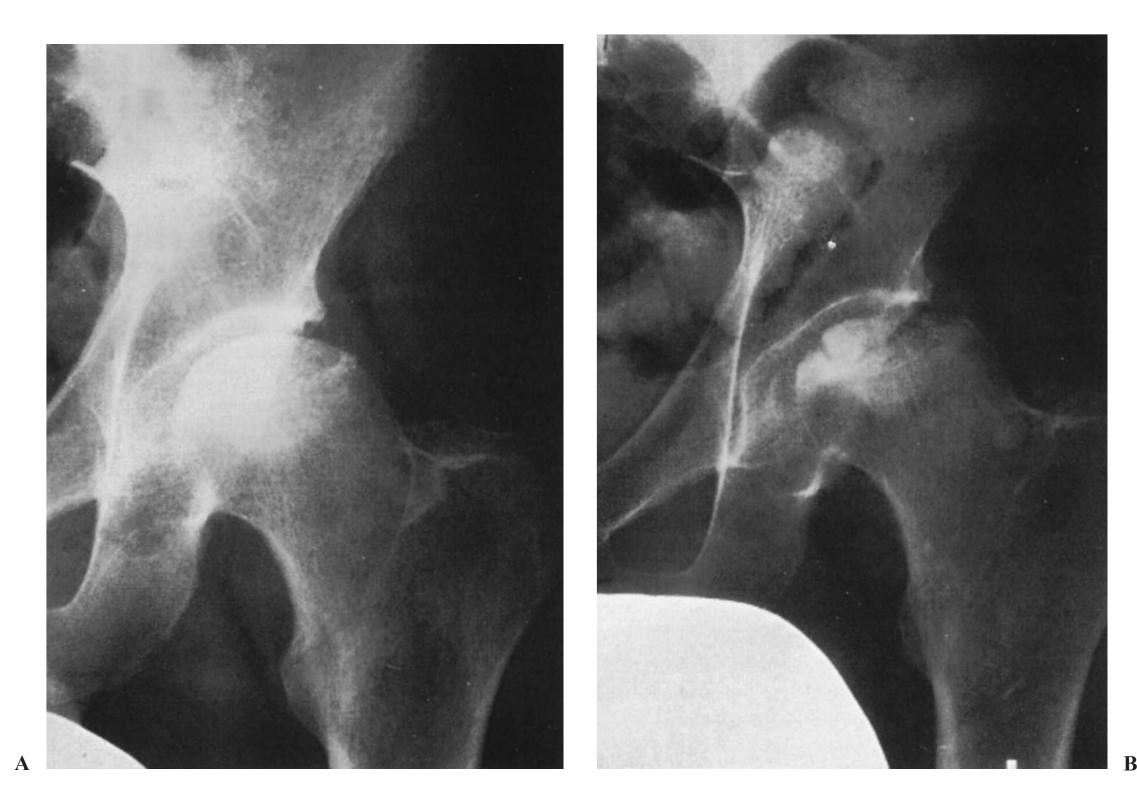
An avascular necrosis of the head of the femur after transplantation. A. A normal radiograph of the hip 10 months after transplantation, at which time the patient was complaining of pain. B. The same hip 8 months later. This patient had received azathioprine and high-dose steroids and subsequently had a successful hip replacement. (From Morris PJ. *Kidney Transplantation: Principles and Practice*. 2nd ed. New York: Grune & Stratton; 1984, with permission.)
